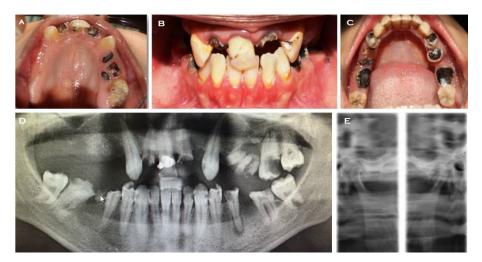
(A) Maxillary arch with few natural teeth remaining (B) Teeth in maximum intercuspation (C) Mandibular arch showing severe decay of posterior teeth (D) Orthopantomograph showing the status of permanent dentition (E) Orthopantomograph of temporomandibular joint
